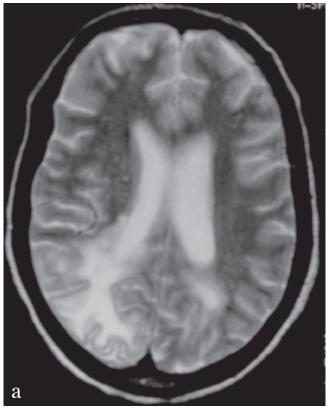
a and b. T2 axial and sagittal MR images demonstrating extensive white-matter hyperintensities involving the frontal, parieto-occipital, and temporal lobes. There is background cerebral atrophy typical of advanced retroviral disease.
